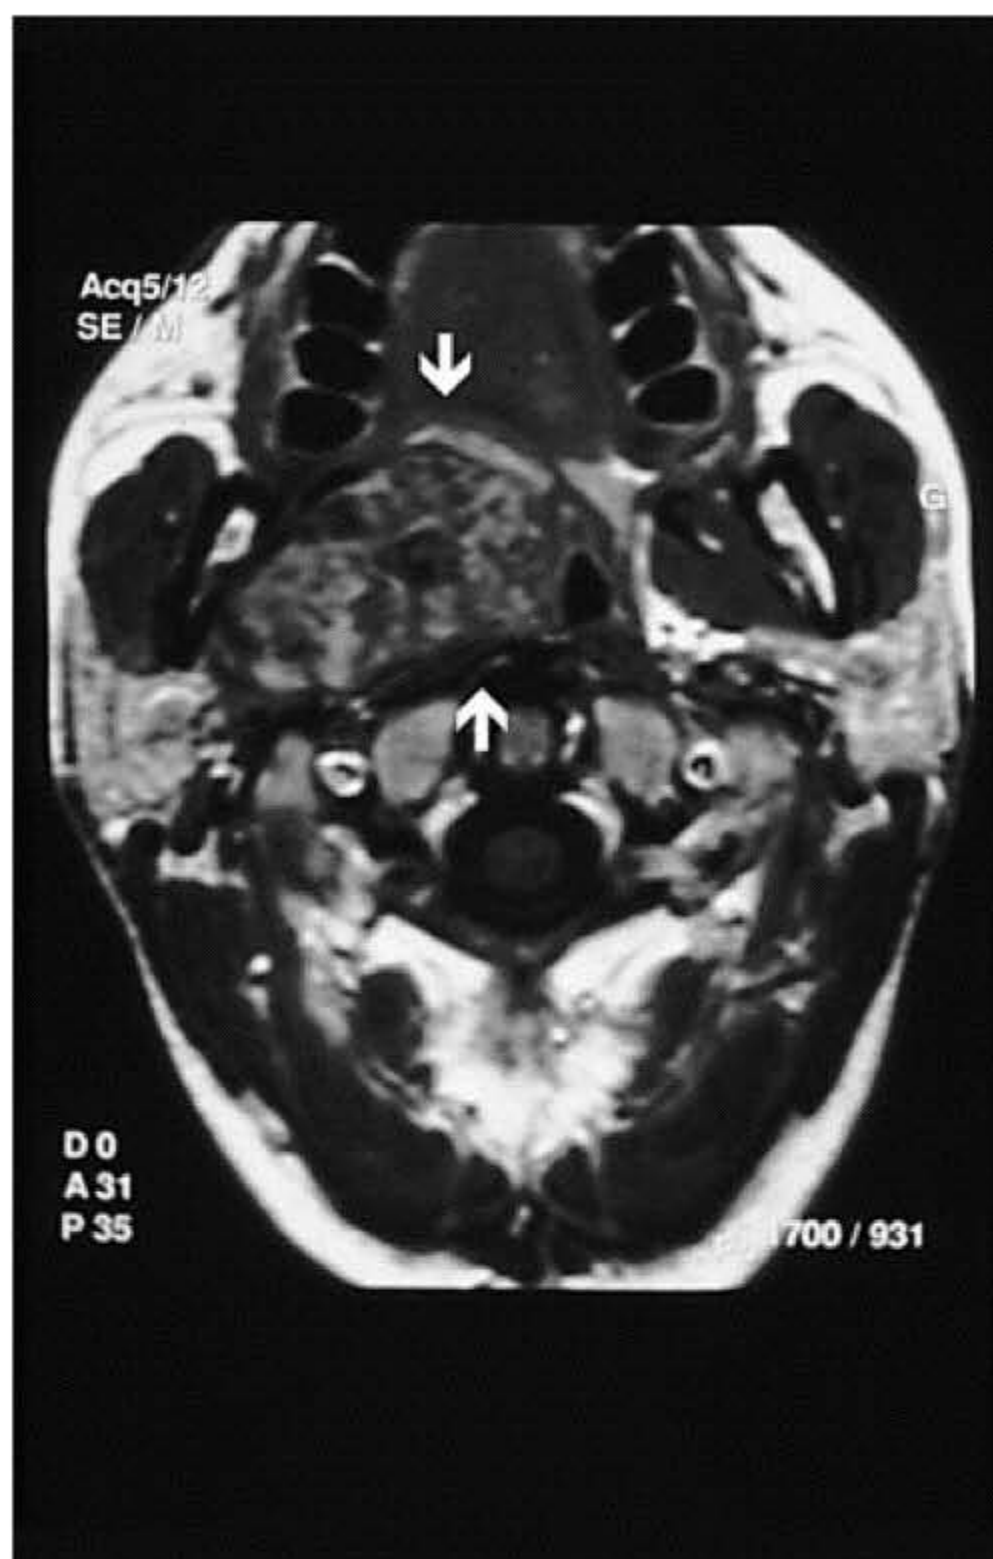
Large tumour (arrows) next to the deep lobe of the right parotid gland, occupying the parapharyngeal space on contrast-enhanced axial T1-weighted MRI.
